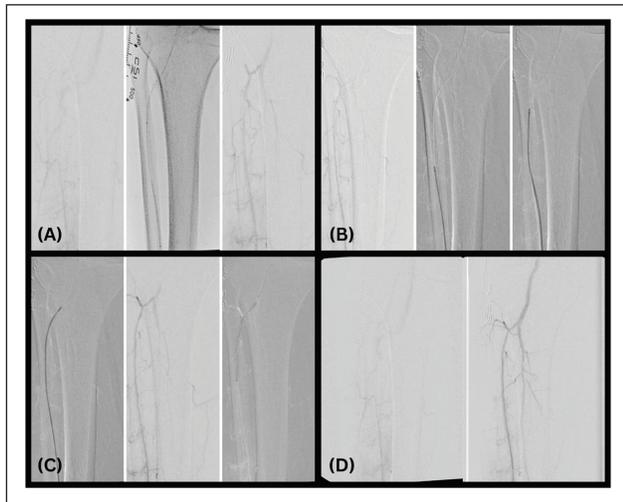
Case 1. (A) An ASAHI Mongo wire crosses a total occlusion of the right proximal ATA. (B) Pilot channel through the lesion created by Phoenix 1.5 mm catheter with a front-end cutting technique. (C) Post atherectomy, an IVUS catheter and an appropriately sized balloon can pass the lesion. (D) Final angiogram showing 0% residual stenosis and TIMI 3 flow as compared to the initial angiogram. ATA, anterior tibial artery; TIMI, thrombolysis in myocardial infarction; IVUS, intravascular ultrasound.
